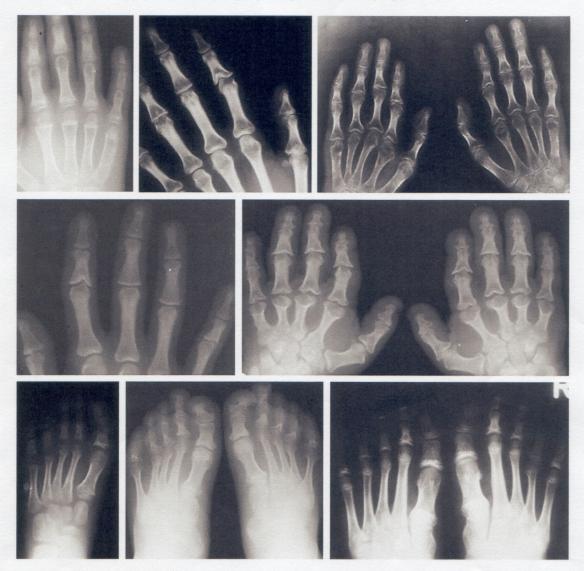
Phenotype in TRPS. Radiology of the distal limbs. Note cone-shaped epiphyses that are most common in the middle phalanx of the second digit, but can be present everywhere. Some radiographs show marked osteopenia.
